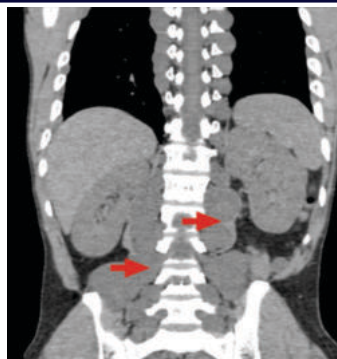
9 CT – coronal section abdomen shows bilateral lobulated para vertebral lesions with neural foramina widening and scalloping of posterior margin of dorsal and lumbar vertebra
